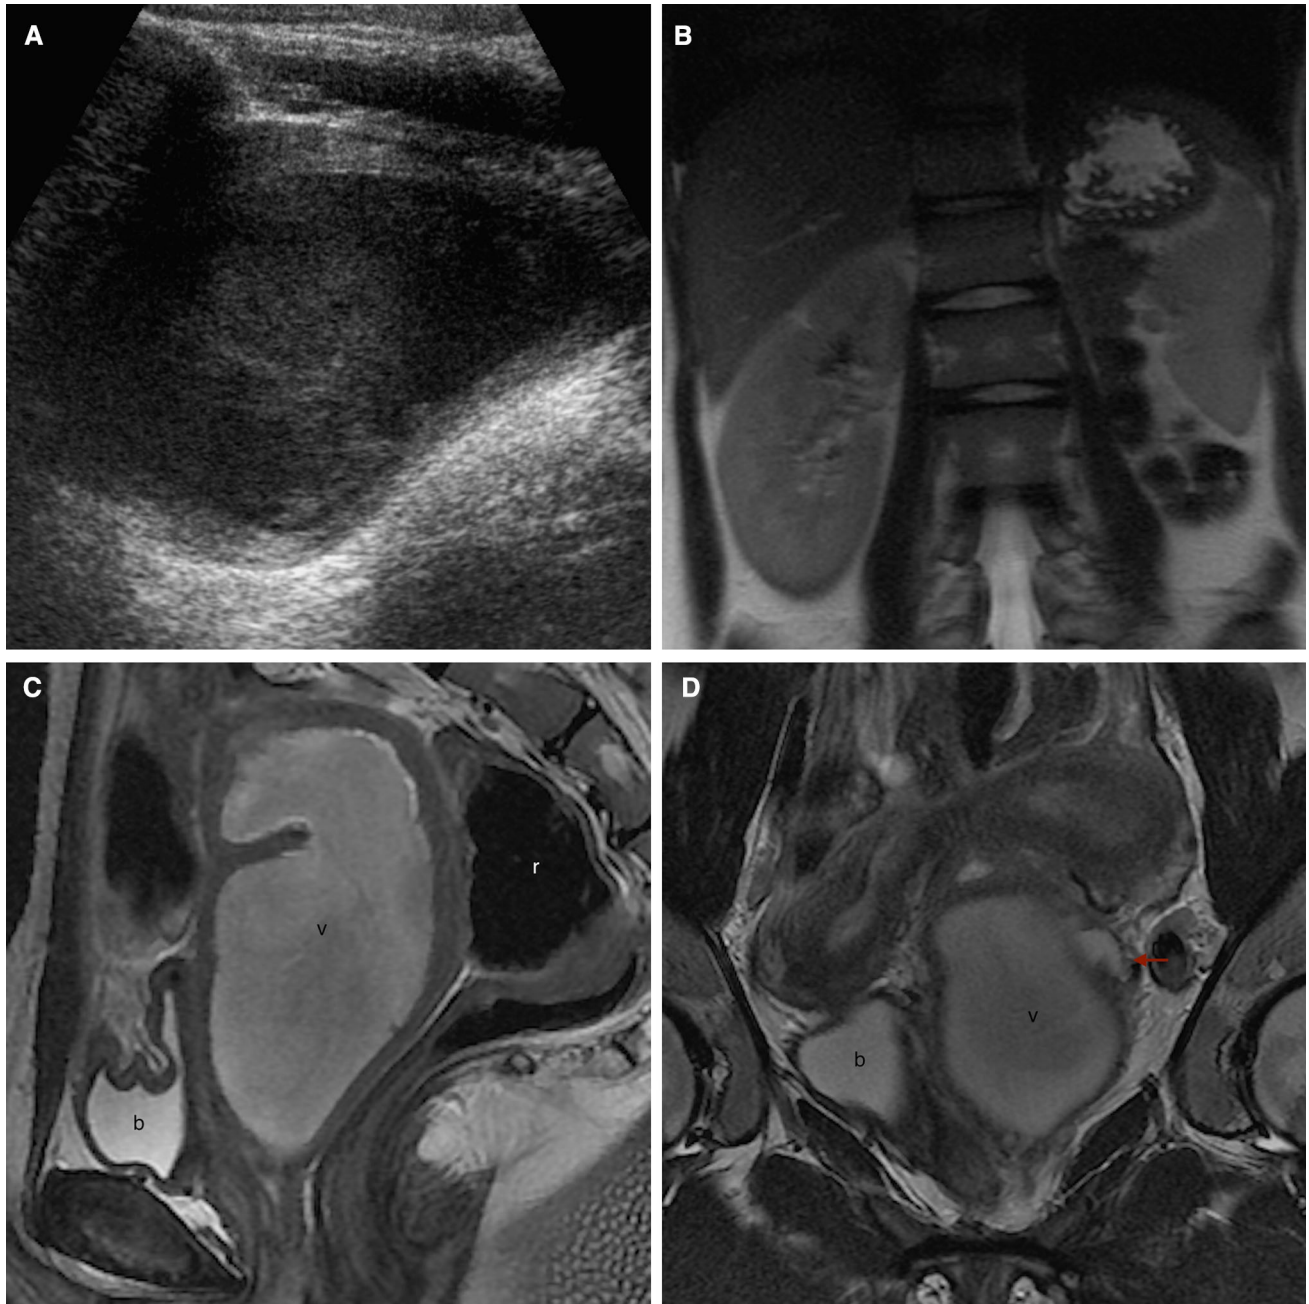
Images in a 16-year-old girl who presented to the emergency department with a 2-month history of severe pelvic pain and anomalous uterine hemorrhage (A US; B coronal T2WI; C sagittal T2WI; D, E coronal T2WI; G coronal T2WI; H axial T2WI). US revealed the absence of the left kidney (not shown) and a pelvic, thick-walled cystic structure with homogeneous, low-level internal echoes, and posterior enhancement (A). MRI showed the left renal agenesis (B), a huge left hematocolpos (C–E v), and a uterus didelphys (D). The non-obstructed right hemivagina (E white arrow) may be also seen. A dilated left ureteral stump (D, E red arrows) is
